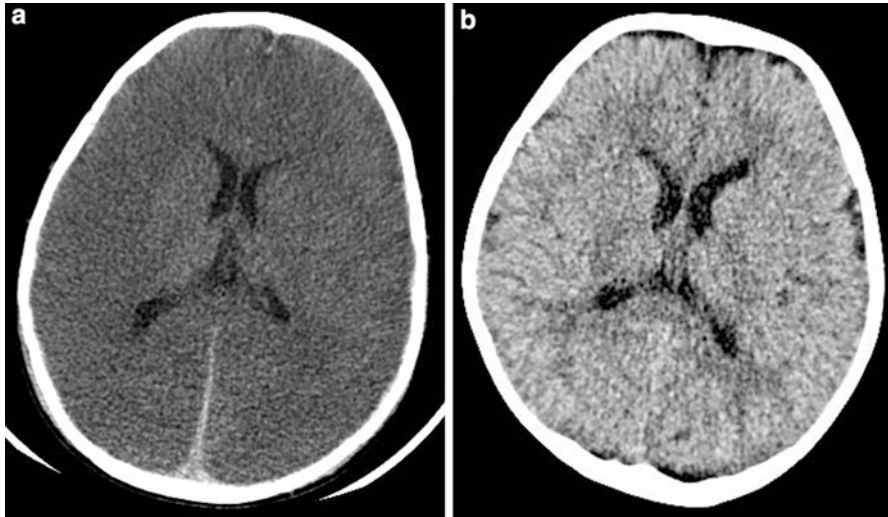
Cytotoxic edema. 18-month-old following nonaccidental trauma. An axial image from a noncontrast CT scan demonstrates diffuse loss of gray matter-white matter differentiation and loss of the normal cortical sulci (a). Compare this study to an axial CT image from a normal infant of the same age (b)
